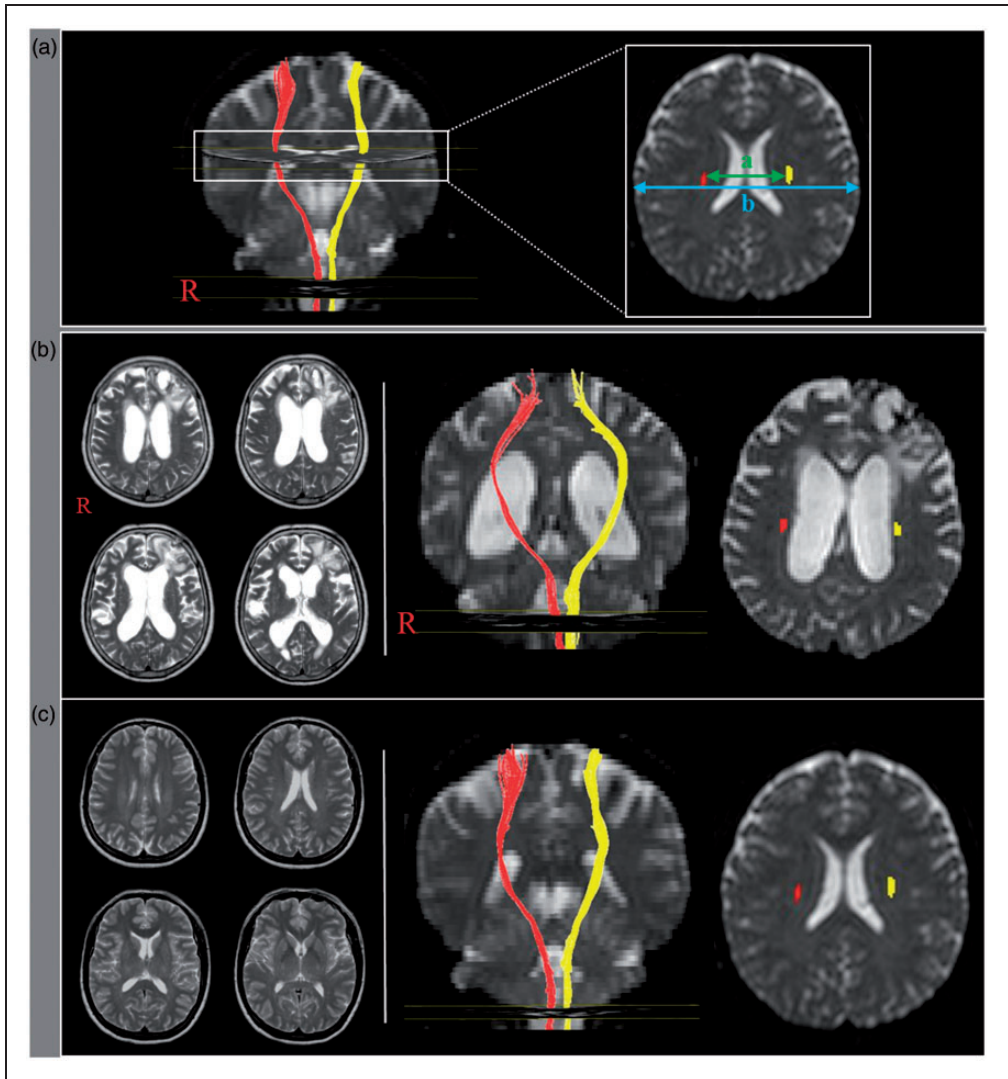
(a) Measurement of the distance either side of the corticospinal tract (CST): green line (a) distance across the CST; sky-blue line (b) diameter across the brain. (b) T2-weighted MRI of a patient showing hydrocephalus and the result of DTT for a CST. (c) MRI of a control, showing no definite lesions and the result of DTT for a CST.
